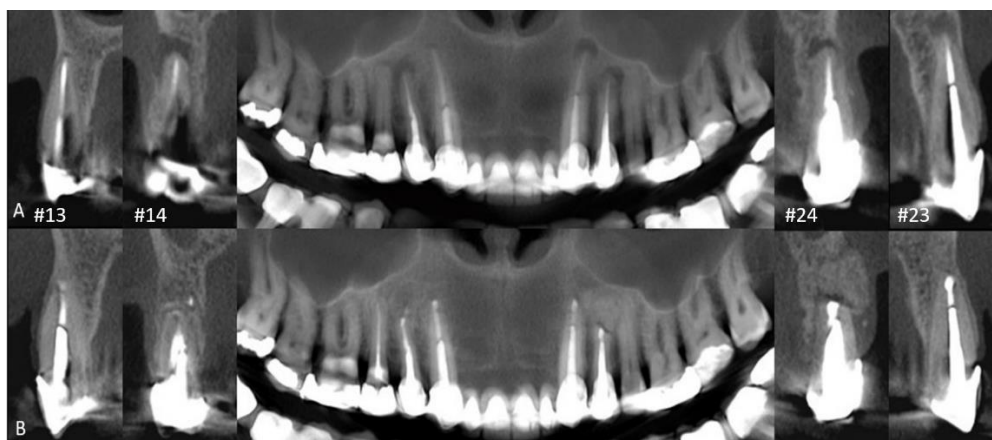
A) Pre-operative CBCT of teeth #13, #14, #23, #24 and #15 demonstrates the presence of apical periodontitis; B) In the twelve-month control CBCT it can be observed complete repair of the referred teeth
